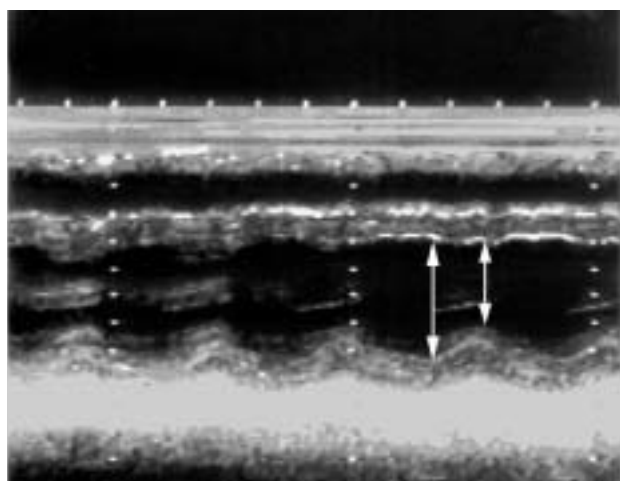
M-mode echocardiogram done when the patient was in the ICU. Arrows indicate the diameters at end-diastole and end-systole of the left ventricle, which were 45 mm and 35 mm, respectively (shortening fraction 22%). Estimated ventricular function was 20%.
